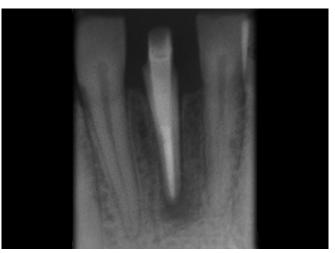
Radiographic control after fiber post cementation and build-up
